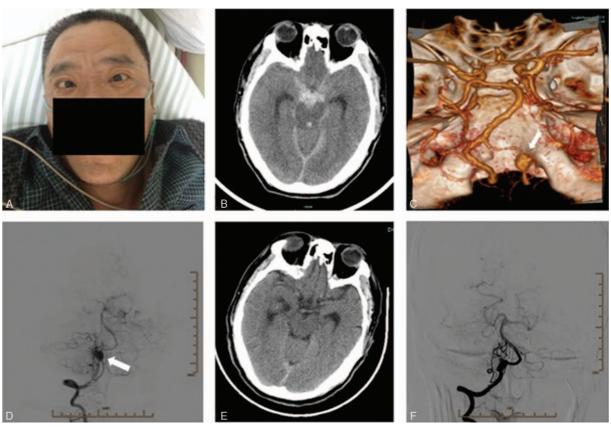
(A) Initial photograph disclosing the bilateral sixth nerves palsy. (B) Emergent CT scan demonstrating thick cisternal hemorrhage, in particular prepotine cistern without ventriculomegaly. (C) Emergent CT angiography demonstrating the aneurysm on the left VA (white arrow). (D) Left vertebral angiography showing a dissecting aneurysm of the VA (white arrow). (E) Resolution of hemorrhage is noted in the prepontine cistern. (F) Postdeployment and coil embolization, DSA revealing complete occlusion of the left vertebral aneurysm. CT = computed tomography, VA = vertebral artery.
